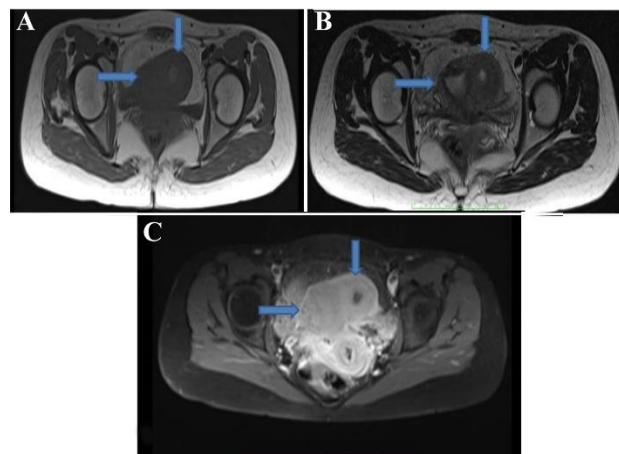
MRI axial images: (A) T1-weighted, (B) T2-weighted, and (C) post -contrast T1 fat-saturated sequences show the uterus (horizontal arrow) and ACUM (vertical arrow). The lesion shows hyperintense contents on both T1- and T2-weighted images, consistent with blood products
